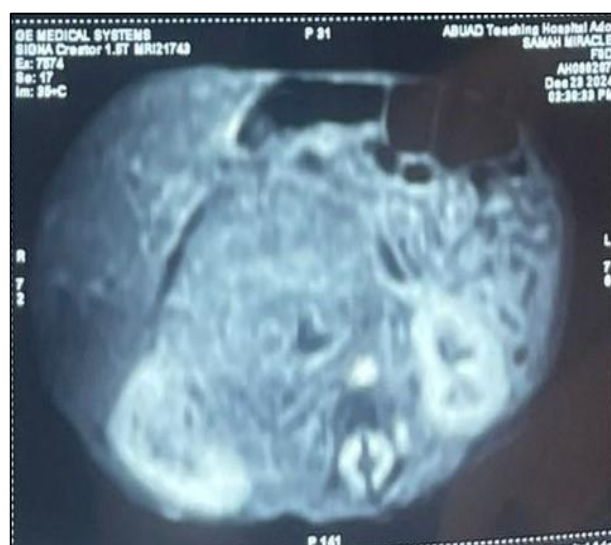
The magnetic resonance imaging (MRI) showing the kidneys with the tumour.
